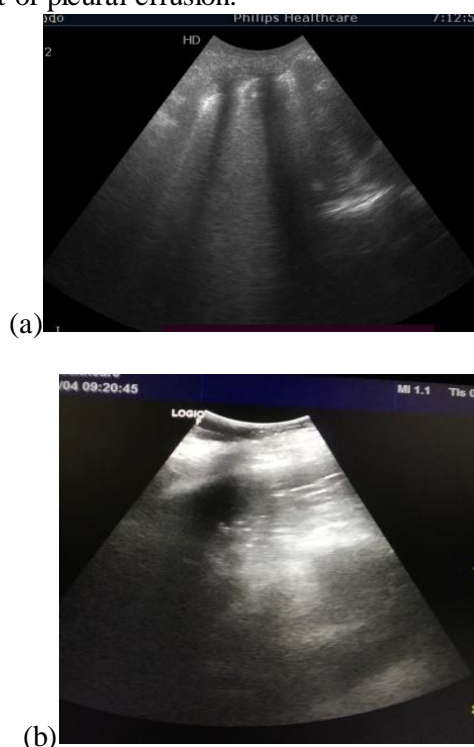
Ultrasound findings in a patient presented with Non-CPE a) Showing AIS, pleural line thickening, and irregularities. Consolidation is present. b) Showing presence of consolidation and pleural effusion.
